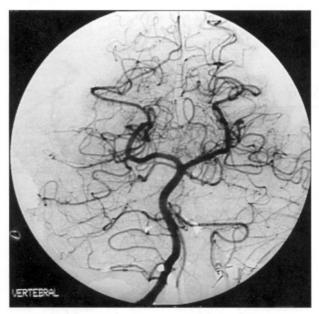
Left: An angiogram obtained 6 months after proximal ligation demonstrates no flow into the left vertebral artery. Right: A T1-weighted MRI image obtained 2 years after surgery shows normal posterior fossa anatomy.
